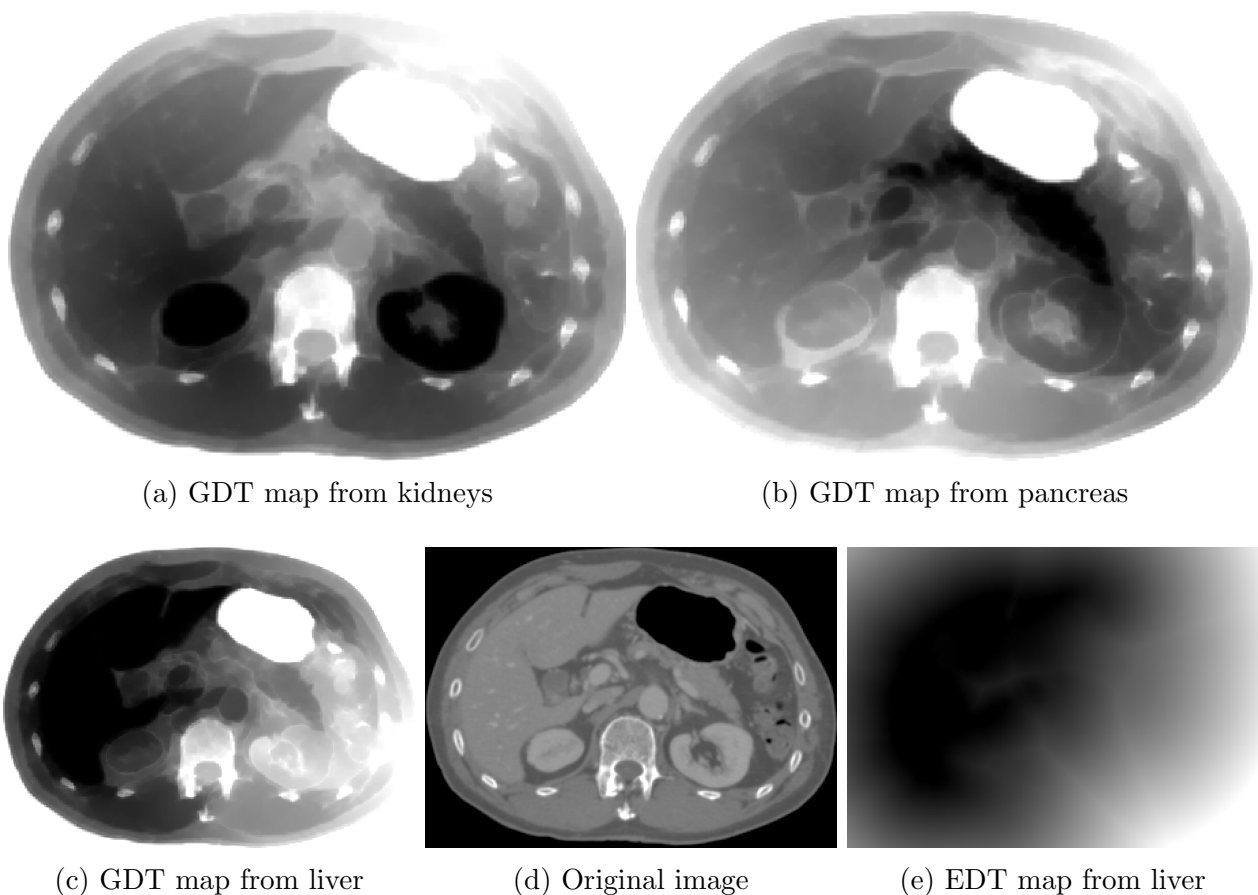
Comparing the EDT to the GDT as distance maps created using eroded ($\times 2$) versions the anatomical structures in abdominal CT images. Distances are shown as being proportional to the intensity.
